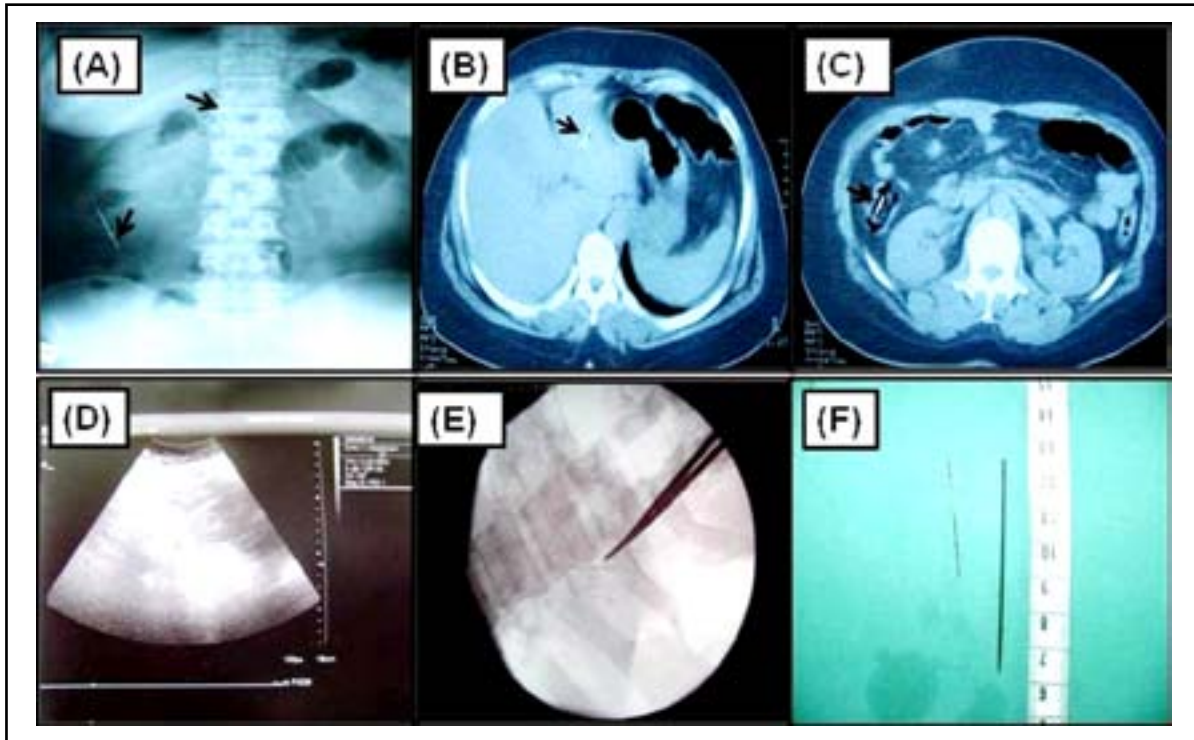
Two sewing needles on Plain abdominal radiograph.
